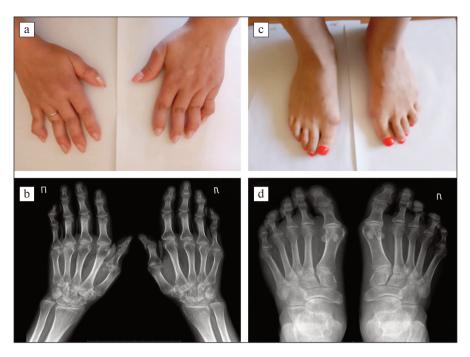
Patient P., 34 years old: a — "swan neck" type deformity of the hand joints; b — X-ray of the hands in direct projection; c — valgus deformity of the first metatarsophalangeal joints; d — radiography of the feet in direct projection (here and in Fig. 2, radiographs from the authors collection are presented)
